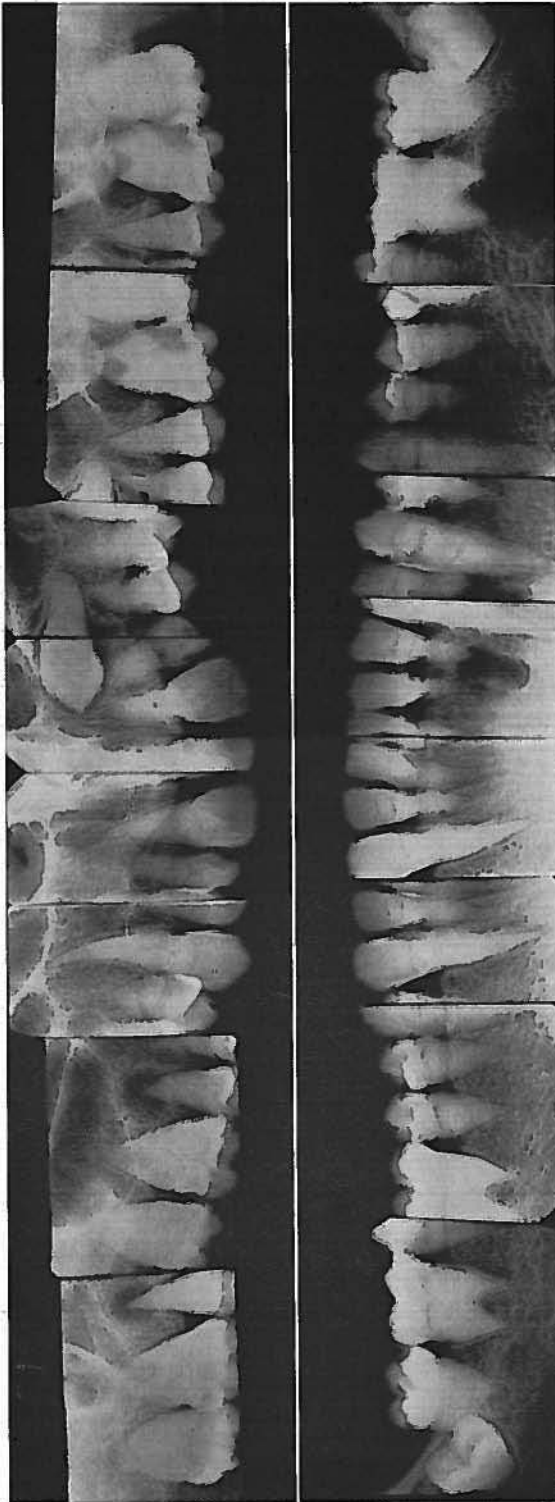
Roentgenograms of 15-year-old son showing similar pattern of pointed root formation, obliteration of pulp canal and multiple periapical roentgenolucencies. Bone structure appears normal.
